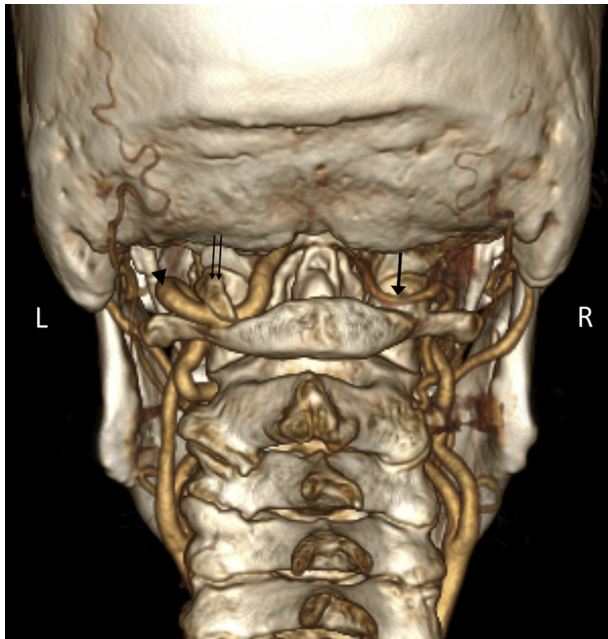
Posterior view of 3D-CTA rendering. The dominant left vertebral artery (arrowhead) can be seen passing underneath a bony bridge that spans between the lateral mass and posterior arch of C1 (double arrows). The atretic right vertebral artery (arrow) can be seen as it wraps around the normal posterior arch of C1.
